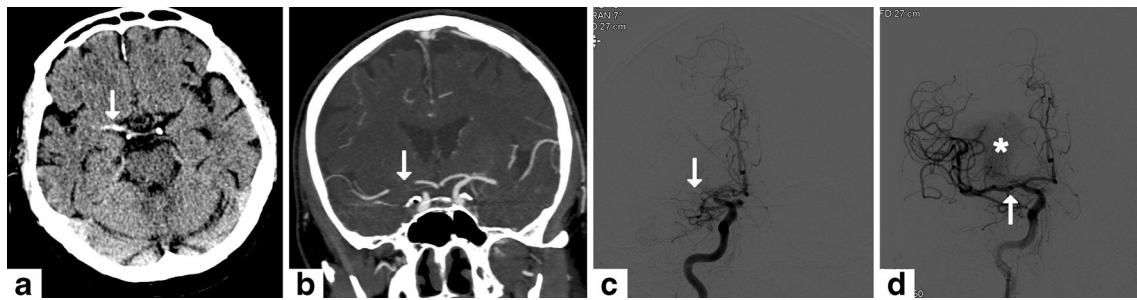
NECT (a), CTA (b), and DSA (c, d) of a 77-year-old male patient. Transverse NECT demonstrates hyperdense M1 segment of the right middle cerebral artery (arrow in a). Occlusion was confirmed by CTA
